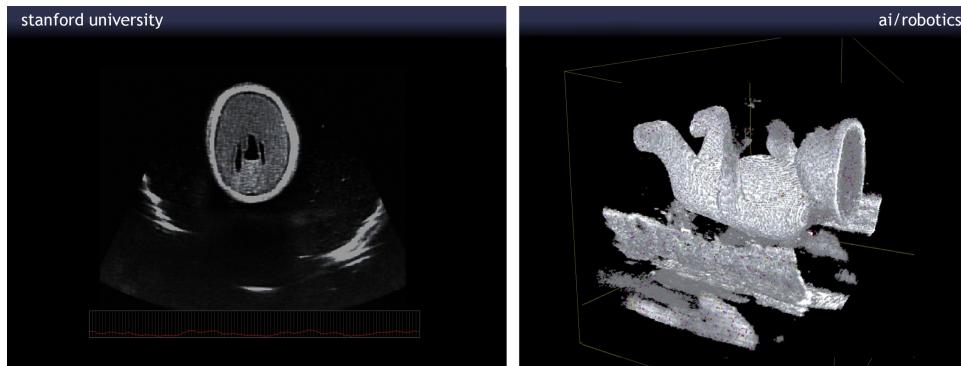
Screenshots of the main user interface. (Left) Live 2D image of the head acquired from the Siemens ultrasound system. (Right) 3D reconstructed view computed in real-time.
